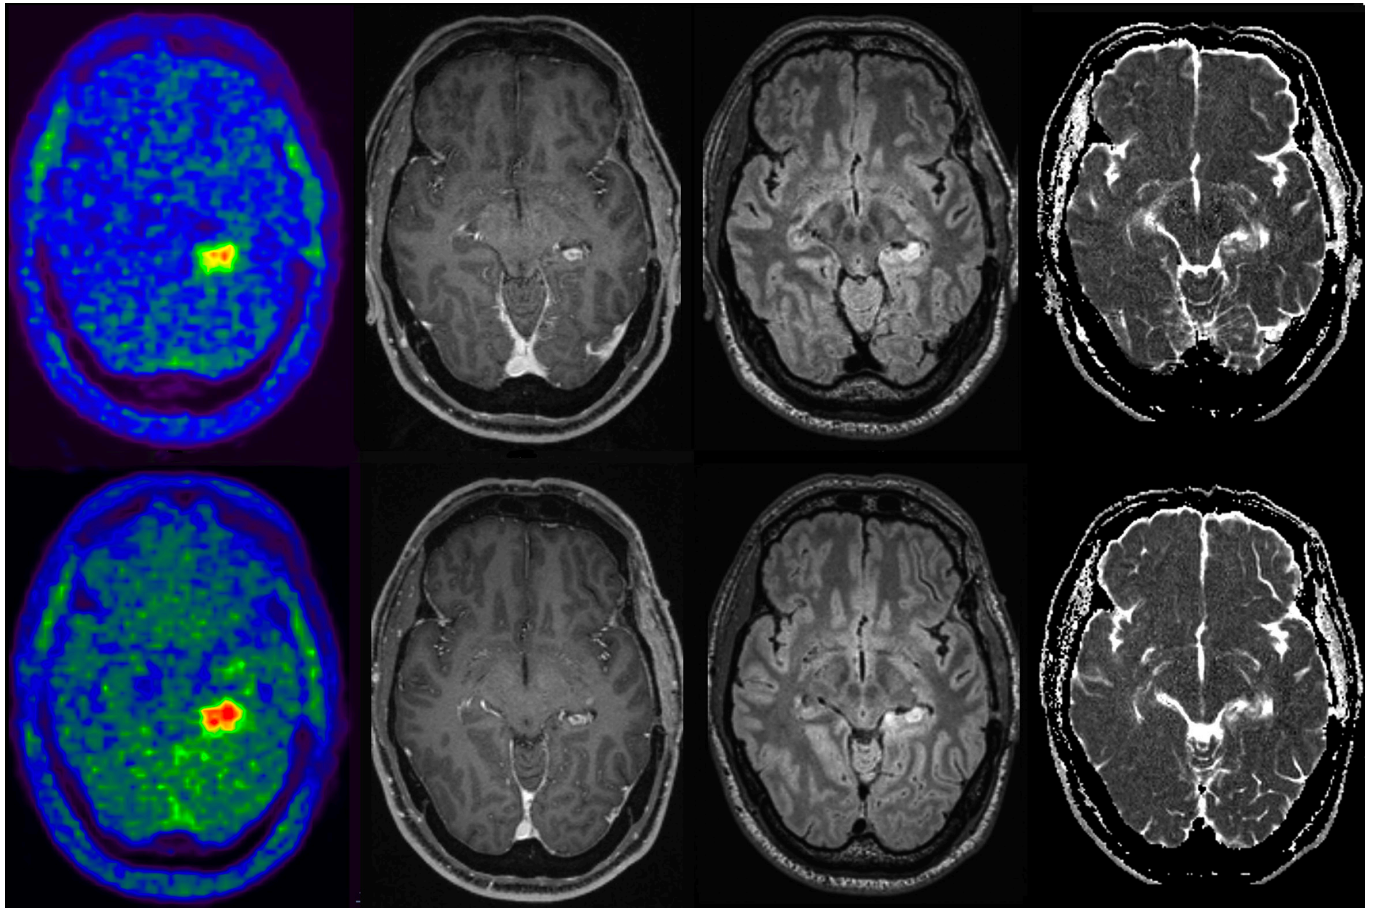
Axial [¹⁸F]FET PET/MR images before (upper row) and after (lower row) treatment with regorafenib in one of the study patients (#5). first column: [¹⁸F]FET PET; second column: post-contrast T₁ weighted; third column: FLAIR; fourth Column: ADC maps. The increase in [¹⁸F]FET uptake after treatment with regorafenib is evident in lower row first column compared with upper row even though no significant increases in the contrast-enhanced and FLAIR altered areas are visible. The analysis revealed an increase in the pathological ADC-volume after regorafenib, even though it was barely detectable qualitatively on the native images. ADC, apparent diffusion coefficient; FET, O-(2-18F-fluoroethyl)-L-tyrosine; FLAIR, fluid attenuated inversion recovery; PET, positron emission tomography.
